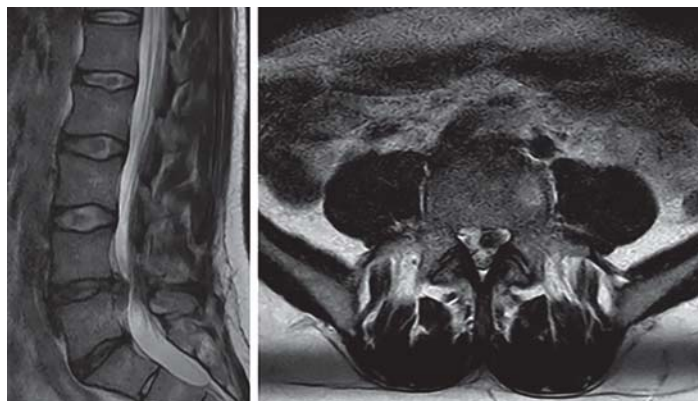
Left: Sagittal T2-weighted magnetic resonance image of the lumbar spine showing disc herniation at L4/5. Right: Axial T2-weighted image showing disc herniation, more pronounced on the left side, with compression of the L5 nerve root.
